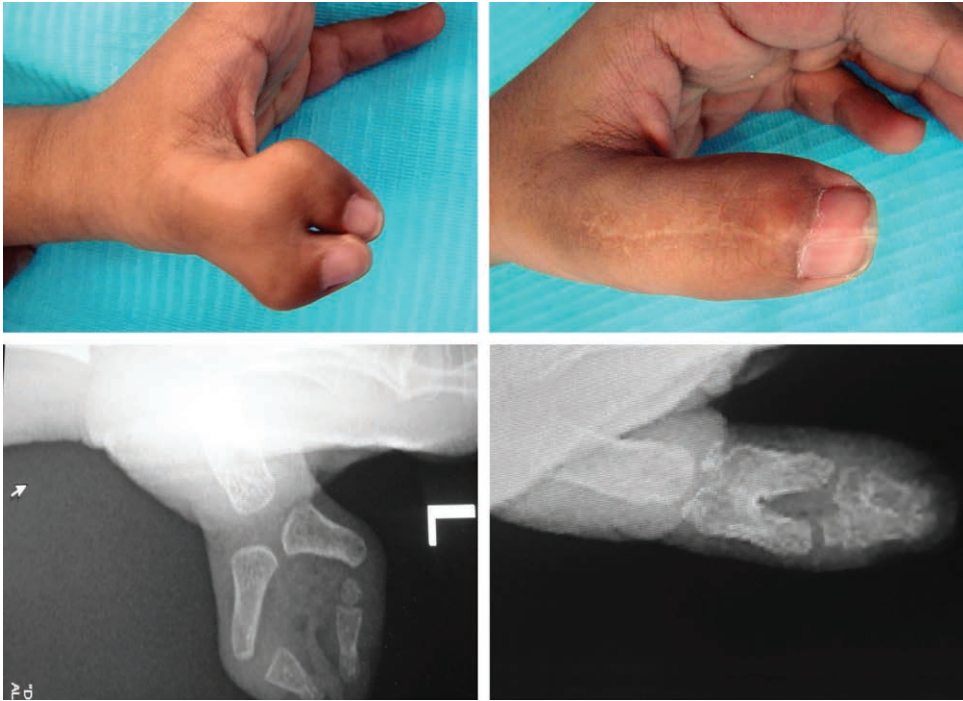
Case 3 with type IV duplication. A, Preoperative appearance, (B) final postoperative appearance, (C) preoperative X-ray, and (D) final postoperative X-ray. There was bony union at the distal and proximal phalanges.
